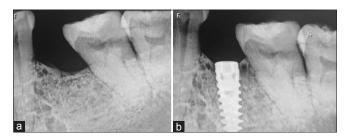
(a) Preoperative radiograph and (b) postoperative 3 months radiograph
